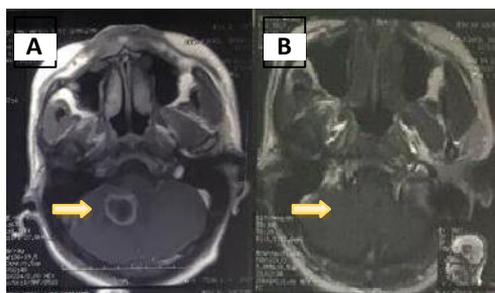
Comparison of the brain MR-imaging in the T1-weighted image before (A) and after (B) ATD treatment for 12 months.
